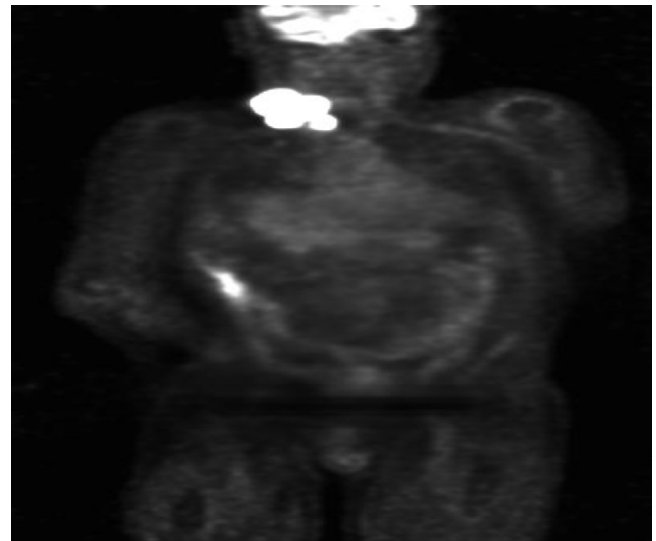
Coronal PET scan displaying 18-FDG avid neck mass and right colon.
